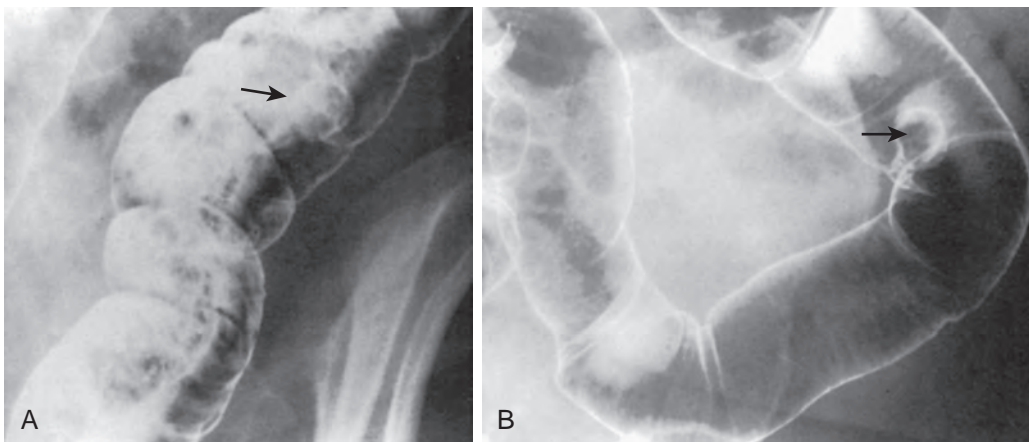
Detection of a polyp despite fecal debris. A. There is considerable fecal debris in the left side of the colon. Nevertheless, a polyp can be recognized as a lesion that is etched in white (arrow). B. After the fecal material has been cleared away, a repeat spot radiograph shows the pedunculated polyp (arrow) more clearly.
